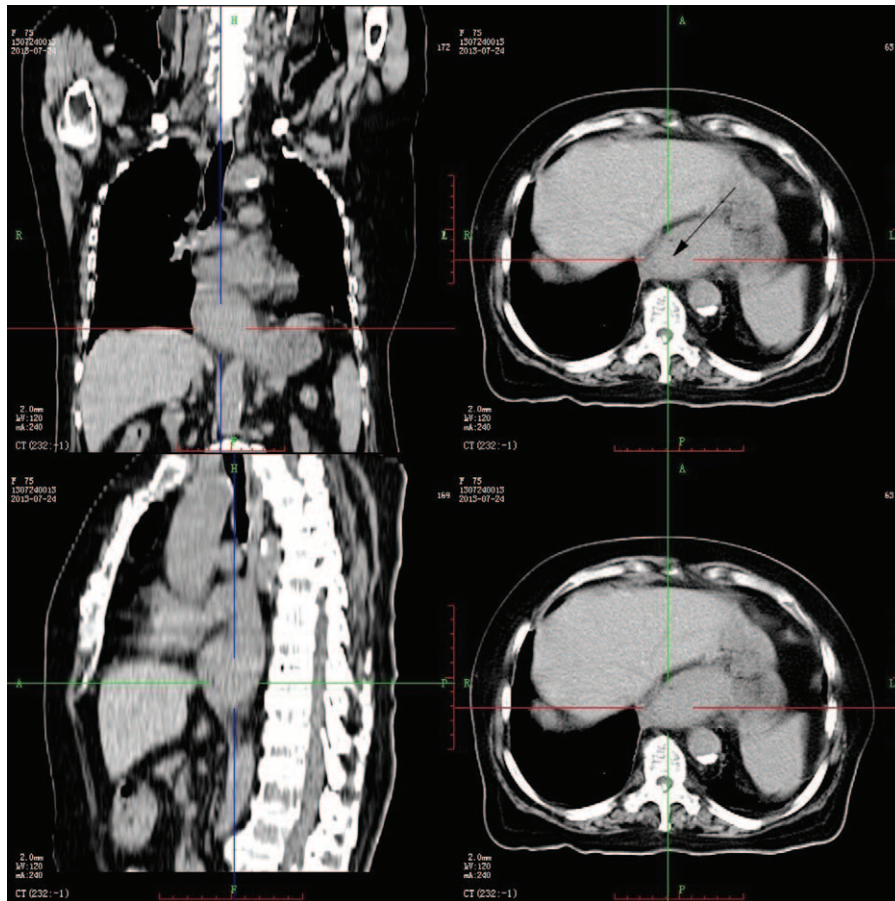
CT showed esophagus thickening (arrowed). Electronic ultrasonic gastroscopy revealed that (A) the esophageal was unobstructed and (B) the tumor body had disappeared. CT=computed tomography.
